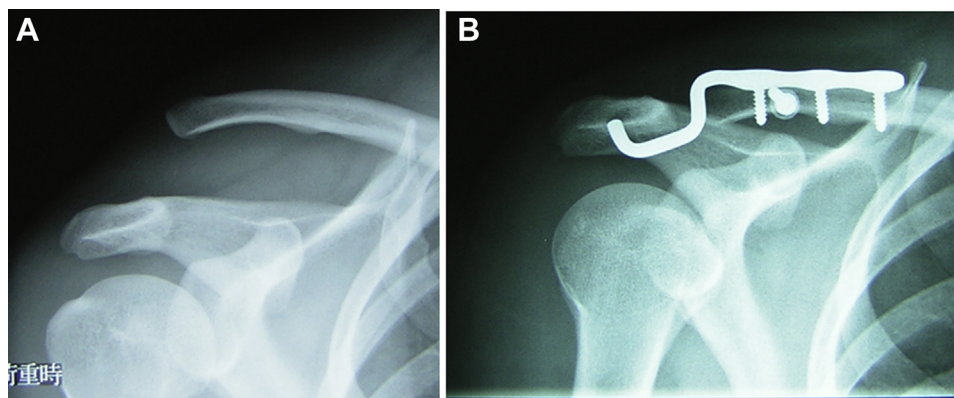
Representative case: 29-year-old male patient. (A) Preoperative radiograph. (B) Postoperative radiograph.
